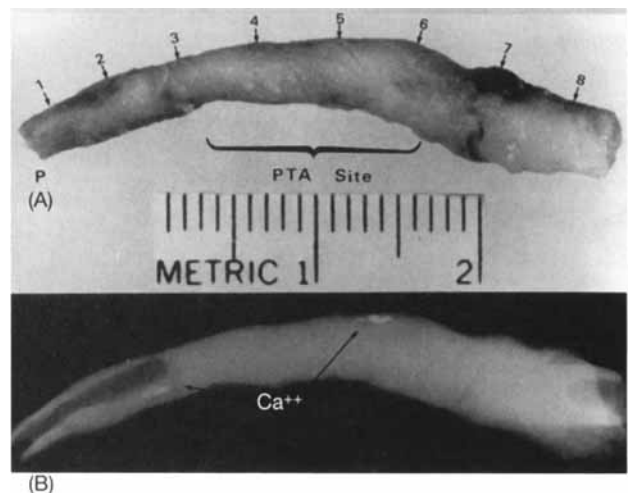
Operatively excised portion of a 56-month-old saphenous vein graft. (A) The brackets indicate the site of two transluminal balloon angioplasty (PTA) procedures located in the midportion of the graft (P = proximal end). The numbers represent sites of transverse sections appearing in Figure 4. (B) Radiograph of transverse section discloses foci of calcific (Ca^{++}) deposits. From Ref. 5 with permission.
